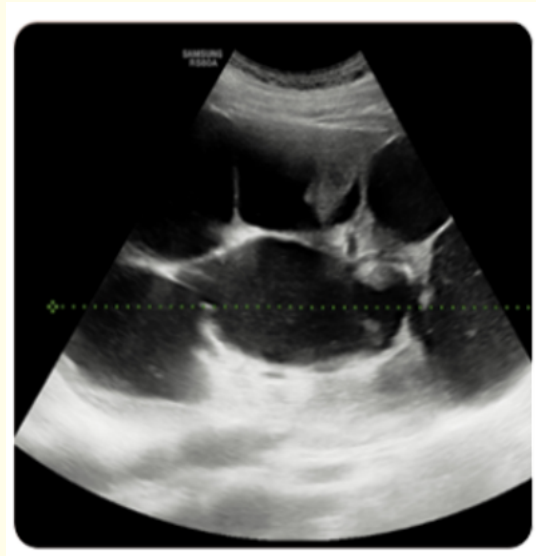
Ultrasound showed very dilated left pelvicaliceal structures with parenchyma thinning and no ureteral dilatation.
